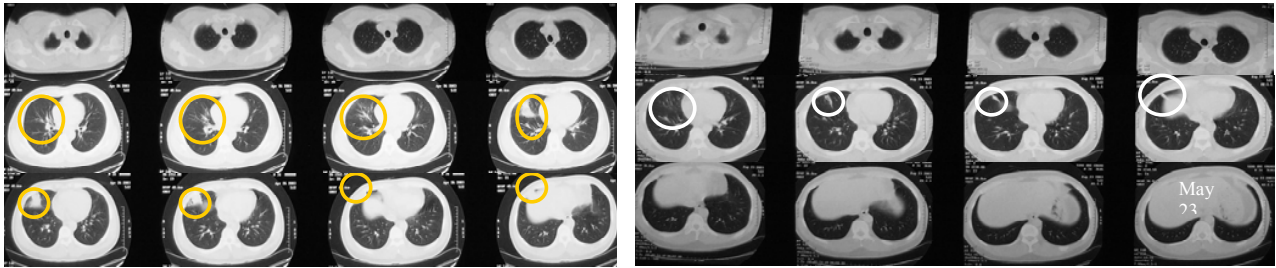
Comparison between CT and TTM in SARS diagnosis – TTM image of May 23, 2003 indicates the abnormal heat pattern of lower right lung lesion which is confirmed by the CT image of the same date. First row: TTM slicing shows the abnormal heat pattern with the depth of heat source 6cm from skin surface; in addition, the subclavian area has a lower temperature than that of the right lung. Second row: (left) CT image of April 26, 2003 showed right lung lesion of SARS progress stage; (right) CT image of May 23, 2003 showed right lung lesion of SARS recovery stage.
